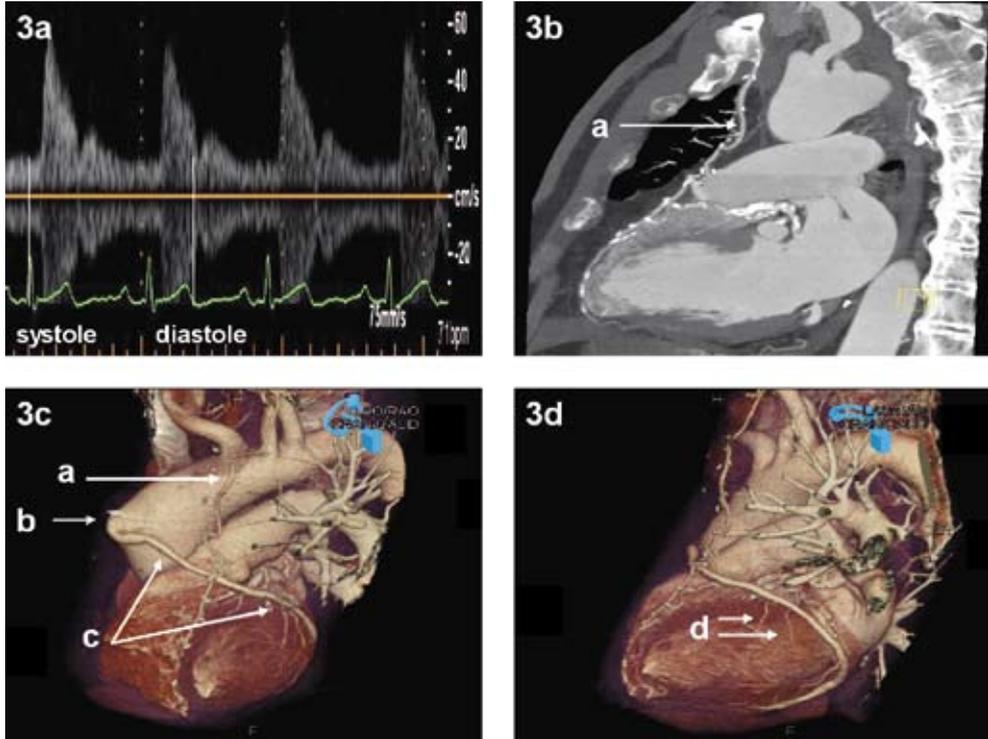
Late follow-up transthoracic ultrasonography (3a) and DSCT coronary angiography of a patent single LIMA graft to the LAD with an additional patent venous graft from the lateral (3b,3d) and anterolateral (3c) view. (a) LIMA graft; (b) proximal venous graft anastomoses to the aorta; (c) patent venous jump graft to the lateral and inferior wall; (d) native obtuse margin branches. LAD, left anterior descending artery. Abbreviations as in Figure 1.
